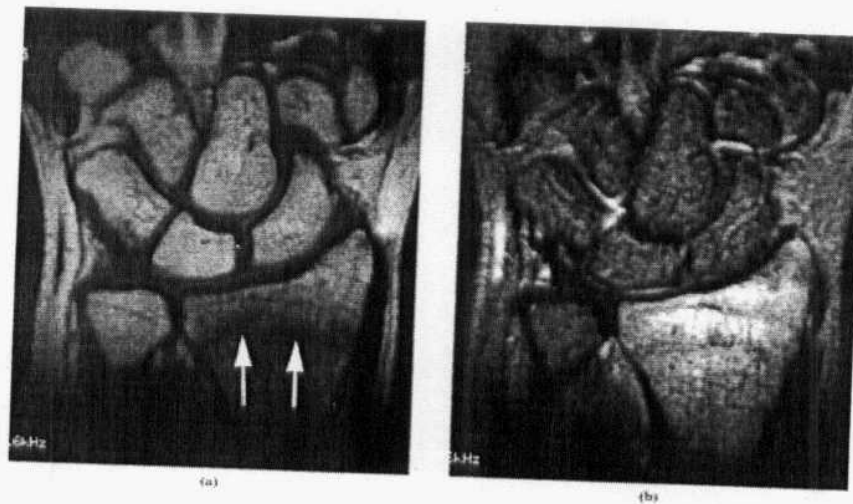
(A) Coronal T_1 weighted image demonstrating a low signal fracture line (arrows) of the distal radius that was radiographically occult. (B) Same patient as (A). Coronal short tau inversion recovery image demonstrating high signal surrounding the distal radius fracture indicating marrow oedema and haemorrhage. (*Quoted from McAlinden , 2001*).
